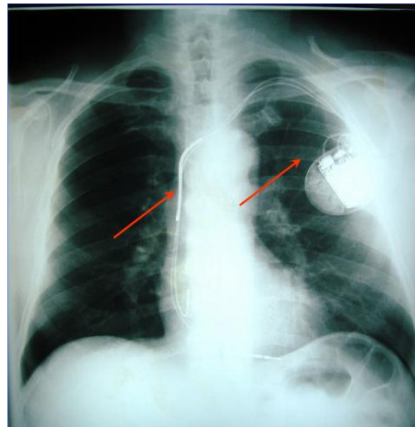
Post-implant chest X-ray reveals leads well positioned
